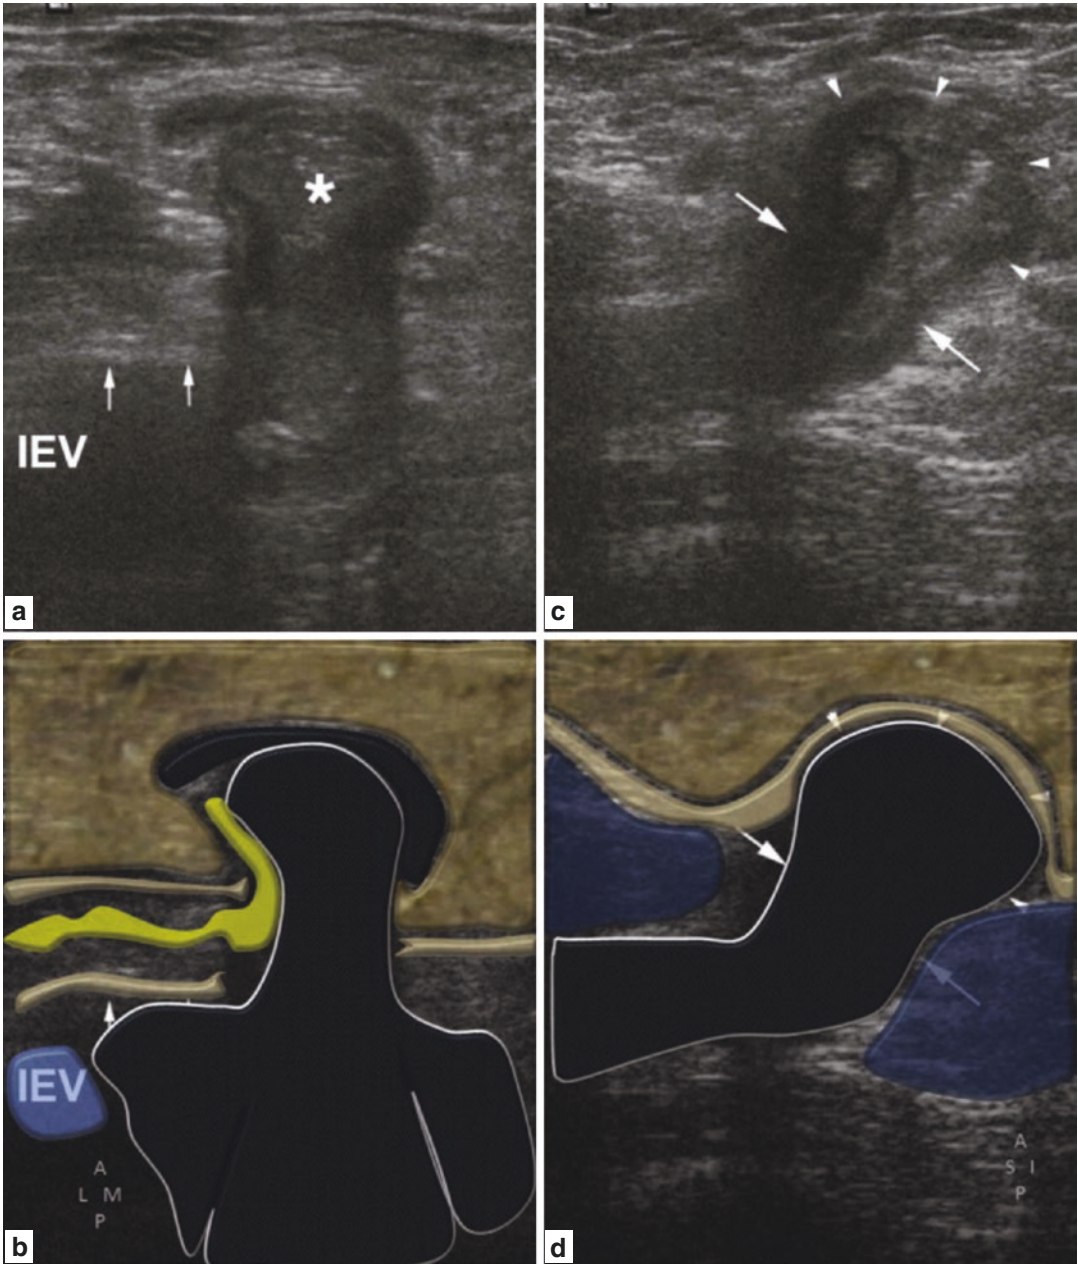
Right direct hernia. (a, b) Transverse sonogram during straining shows the IEVs and adjacent transversus fascia (arrows) lateral to a hernia of bowel and fat (*) entering through the posterior wall defect. (c, d) Corresponding sagittal sonogram shows hypoechoic loop
